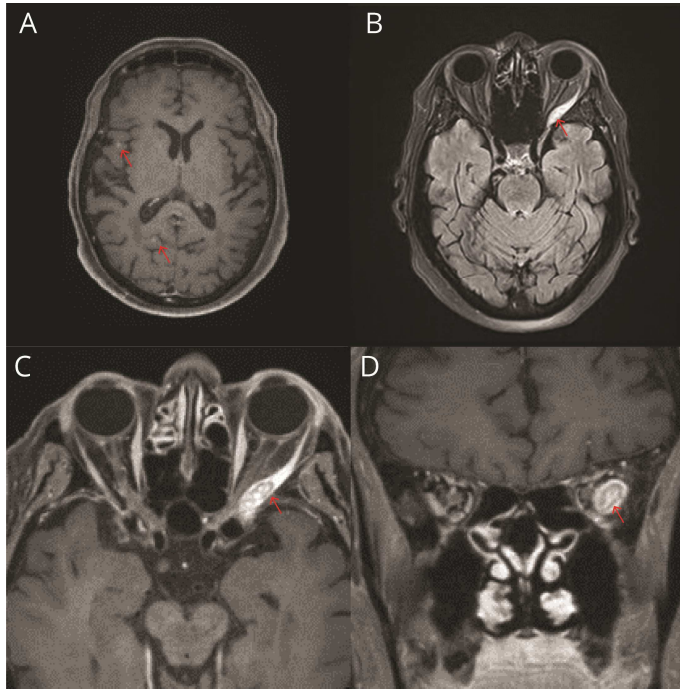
MRI of the brain and orbits
